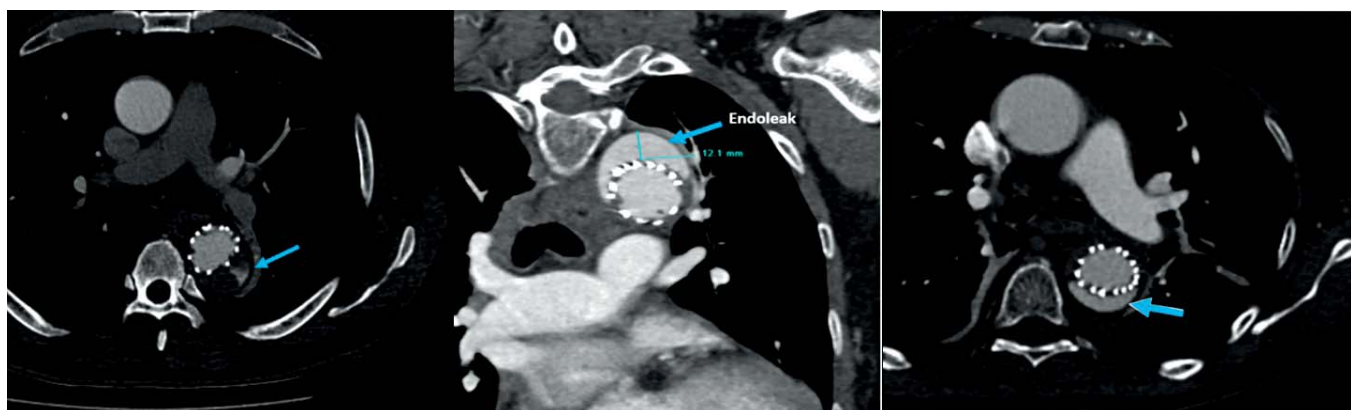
CT scans of different endoleaks
